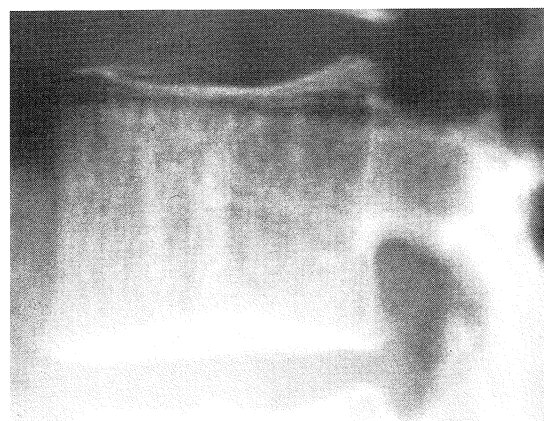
Radiograph showing the typical “corduroy” appearance of non-aggressive vertebral haemangioma.
